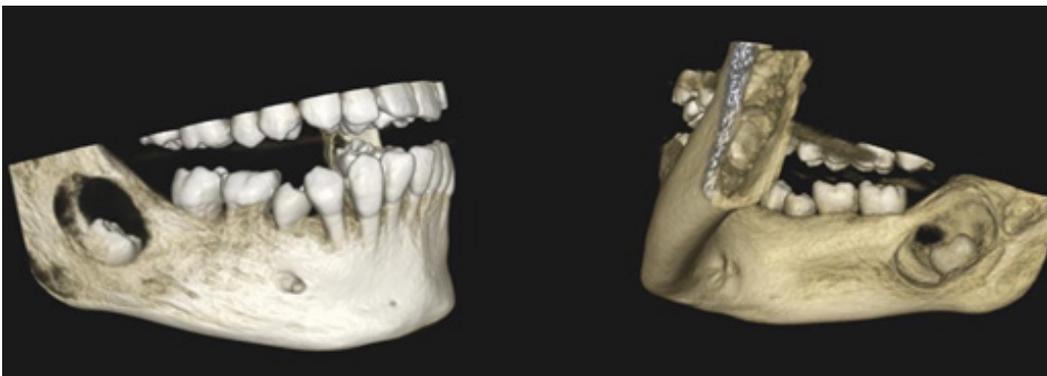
3D view in CBCT showing perforation of cortical bones from vestibular and lingual sides by the lesion.
